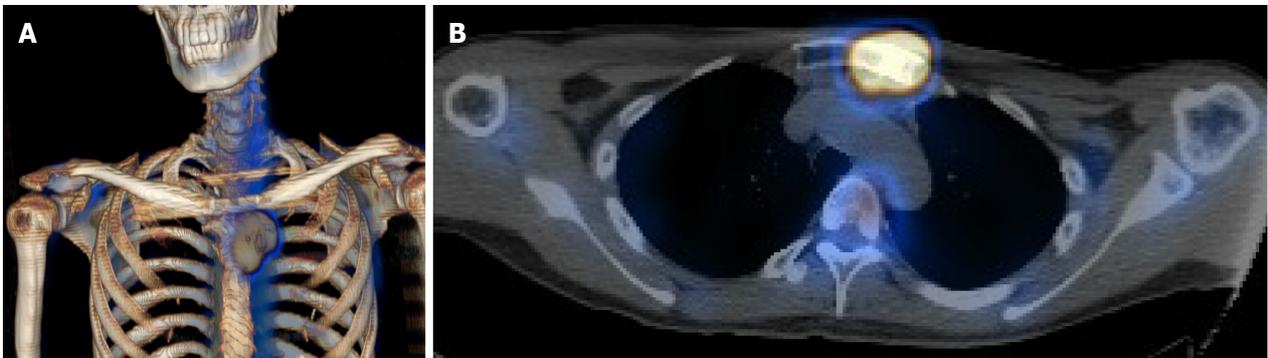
Hypermetabolic mass overlying the upper sternum. A and B: Three-dimensional reconstruction and axial view of positron emission tomography-computed tomography image.
